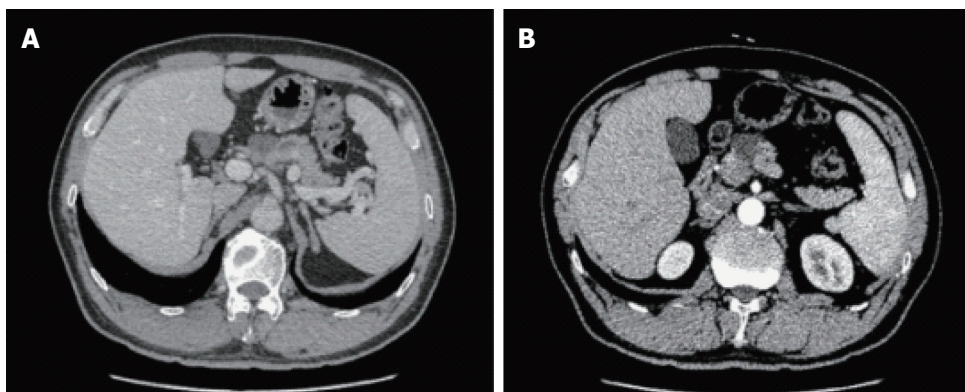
A macrocystic pancreatic serous cystic neoplasm was detected on computed tomography with (B) and without enhancement (A).
